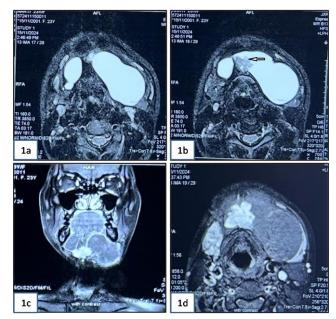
(a, b): Coronal and axial sections of contrast enhanced MRI neck shows bilateral plunging ranula in the sublingual space with enhancement of the mass lesion along infero-medial aspect of left ranula seen extending across midline into the right side cyst. (c, d): T2 weighted axial images of neck MRI shows bilateral plunging ranula in the sublingual space anterior to the carotids with an irregular soft tissue intensity mass lesion along infero-medial aspect of left ranula (arrow).
